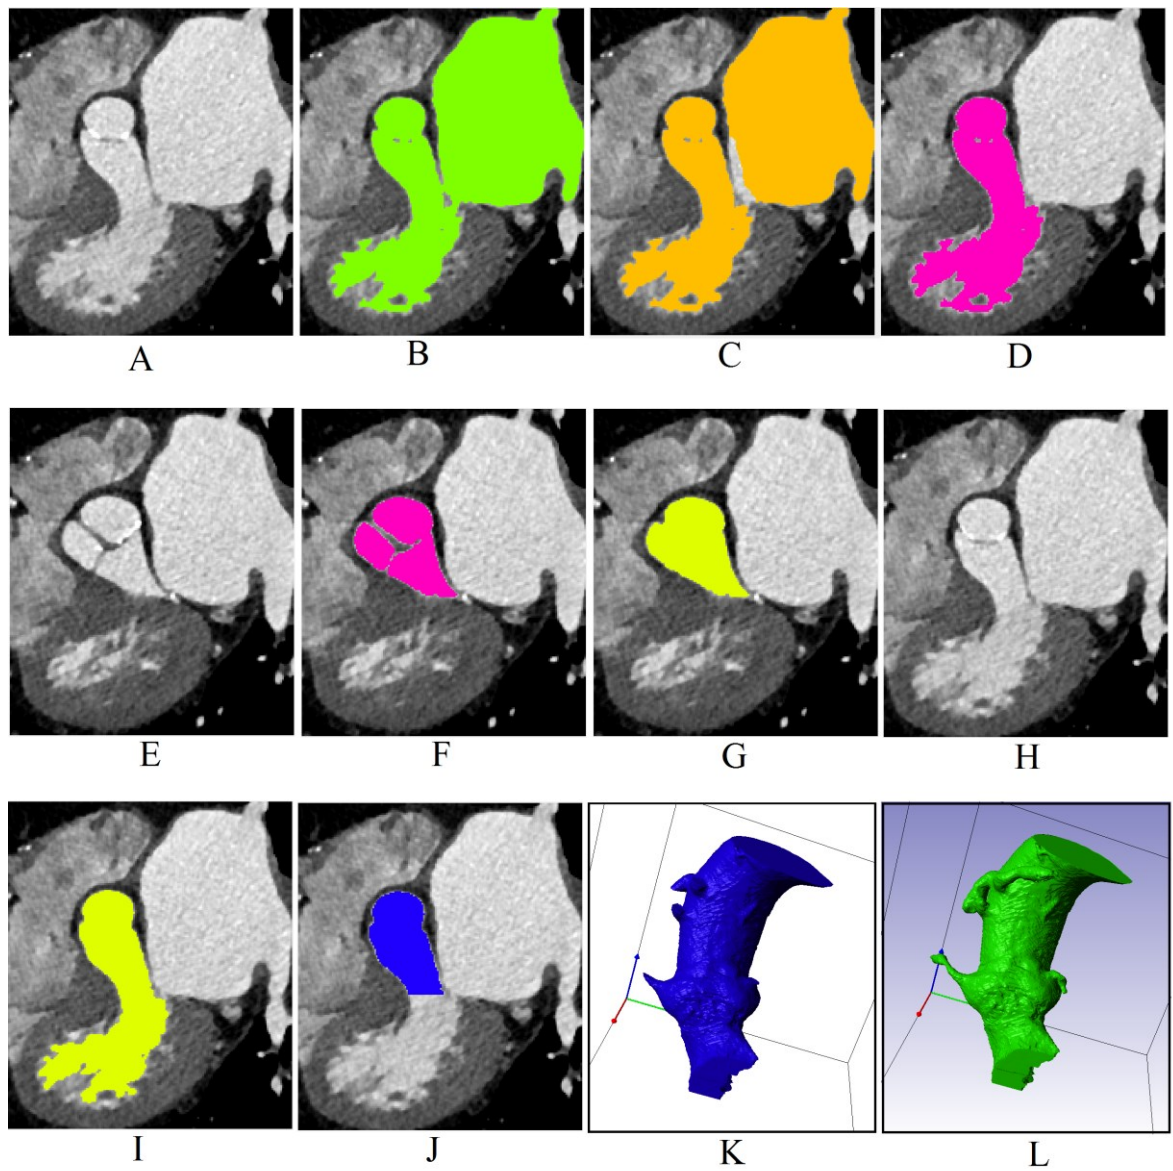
Medical CT images with the following masks highlighted: No mask (A), Mask R1 (B), Mask R2 (C), Mask R3 (D), No mask (E), Mask R4 (F), Mask R4 (G), No mask (H), Mask R4 (I), Mask R5 (J), 3D render of Mask R5 (K) and Mask R6 (L).
